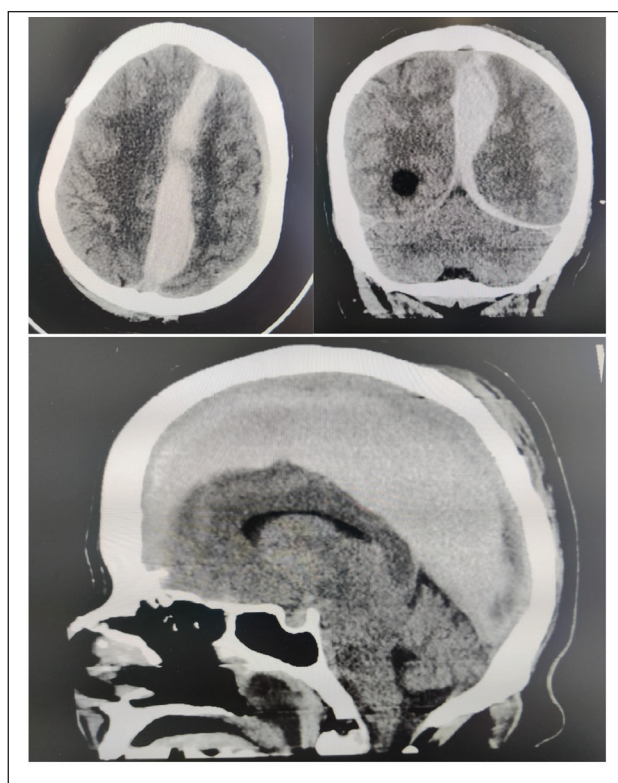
Preoperative CT scan images revealing an ISDH with 20 mm maximal thickness in the coronal plane, conditioning a 22.13 mm midline shift to the right.
